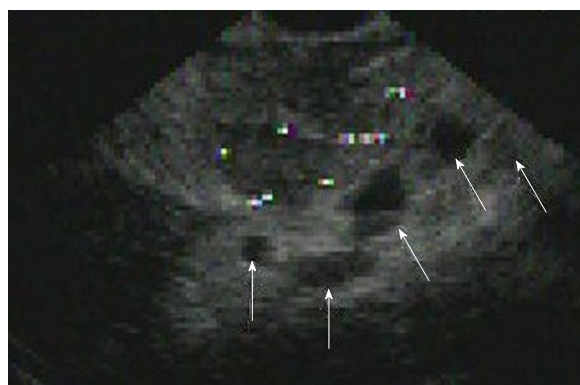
Endoscopic ultrasound image depicting multiple hypo-echoic lesions throughout the pancreas (arrows).
